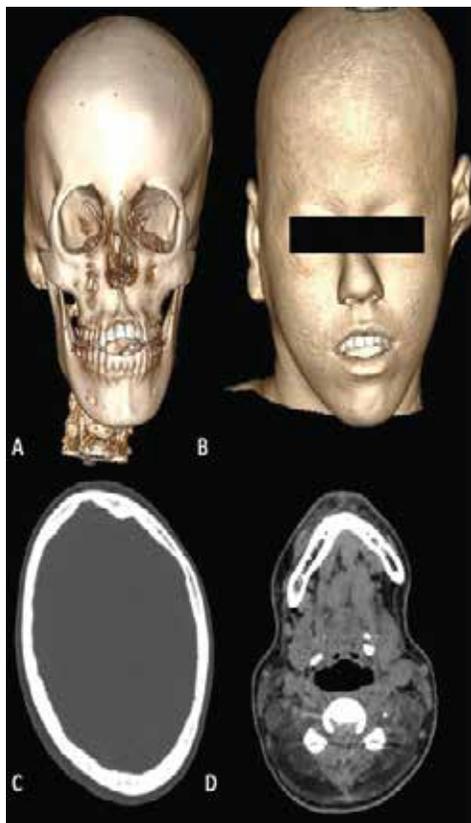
Multiple CT Images of Head; A- 3D skull reformat and B- Volume Rendered image of Face shows features of craniofacial dysmorphism, C- Axial bone window shows dysmorphic shape of skull, D- Axial soft tissue window shows lipomatous degeneration of posterior cervical muscles.
